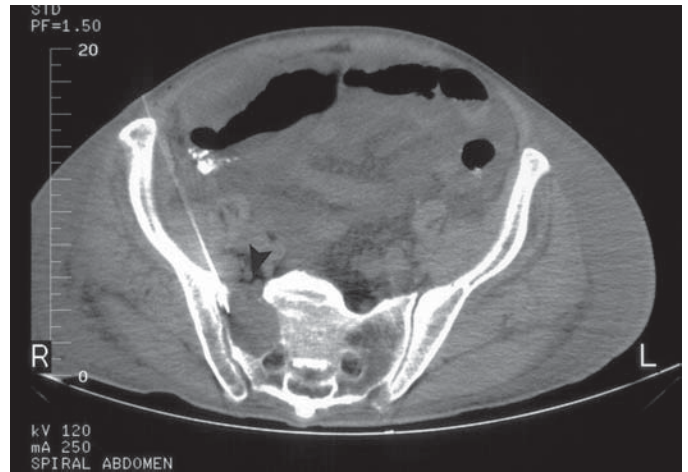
CT-guided direct anterior approach to sacral lesion using FNA needle.
